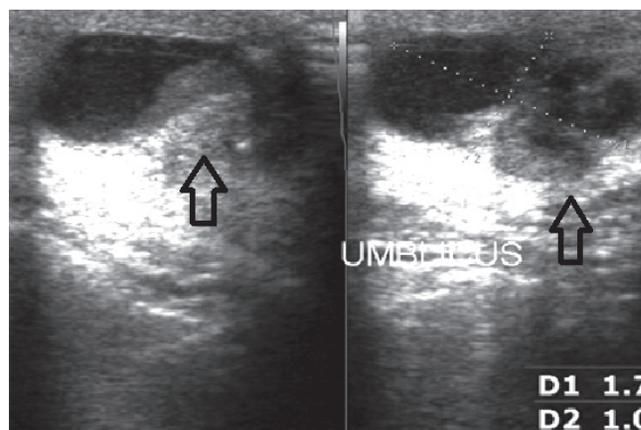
2D ultrasound of umbilical endometrioma of mixed cystic and solid pattern (arrows)
